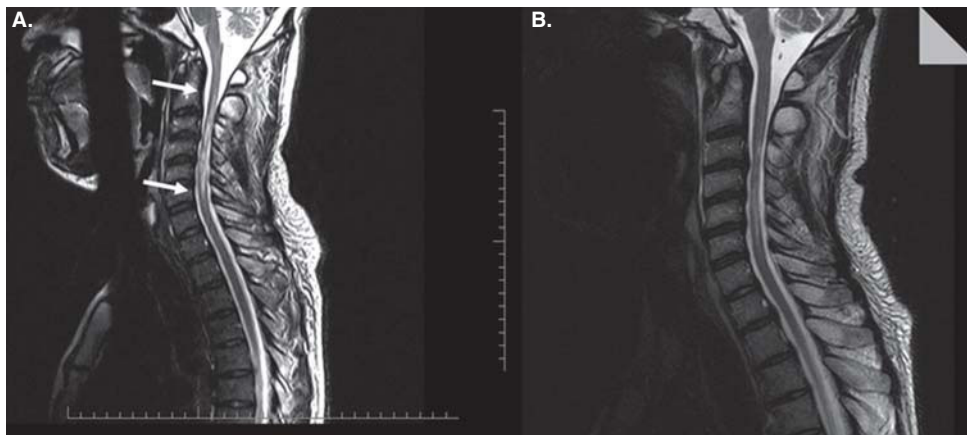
Case 2. (A) MRI of cervical and upper thoracic spine. T2-weighted sagittal view showed increased signal within the cervical cord extending from C2 to C6–C7 (white arrows), with associated cord expansion. (B) MRI of cervical and upper thoracic spine performed 4 months after scan in A. T2-weighted sagittal view showed cord atrophy and increased signal within the cervical cord extending from C3 to C6.
